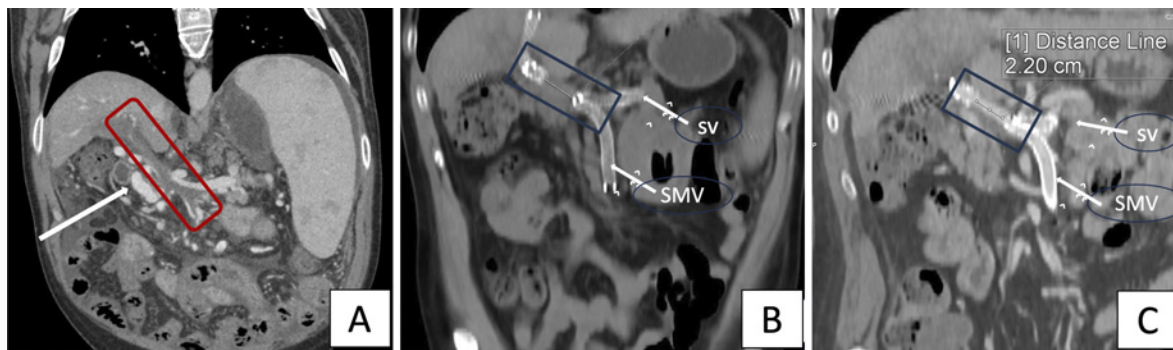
(A) Red box showing extensive thrombosis of main portal vein extending into superior mesenteric vein and splenic vein. Notice a large collateral vessel (white arrow) in the periportal region. (B and C) Status post-portal vein recanalization with transjugular intrahepatic portosystemic shunt (post-PVR-TIPS), pre-transplant patient with plain (B) and contrast (C) coronal reformatted CT images showing >2 cm stent-free, recanalized extrahepatic main portal vein (black box), meeting the needs for clean anastomosis during transplant. Notice the TIPS stent along with recanalization and stenting of the splenic vein (SV) and superior mesenteric vein (SMV).
